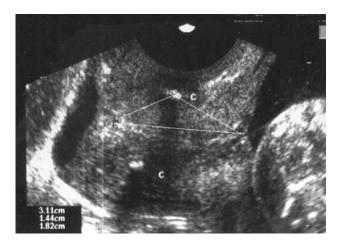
Transvaginal sonogram of a cervix after performance of a Shirodkar cerclage demonstrating sufficient distances to the internal and the external os
